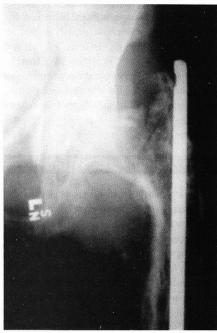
AP X-ray of the left hip in a 71 year old male with Paget's disease. The patient suffered a midshaft femur fracture five years prior which was treated with an intramedulary rod. He presented with a minimally displaced femoral neck fracture with the joint preserved.
